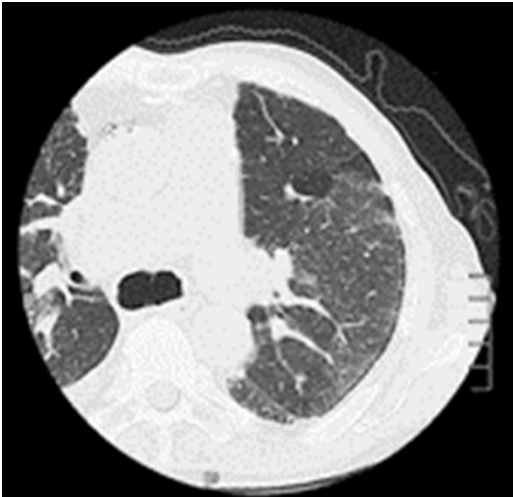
HRCT showing fibrosis as comparatively light areas. Along with subpleural dots and subpleural curvilinear lines a mosaic pattern is observed.
